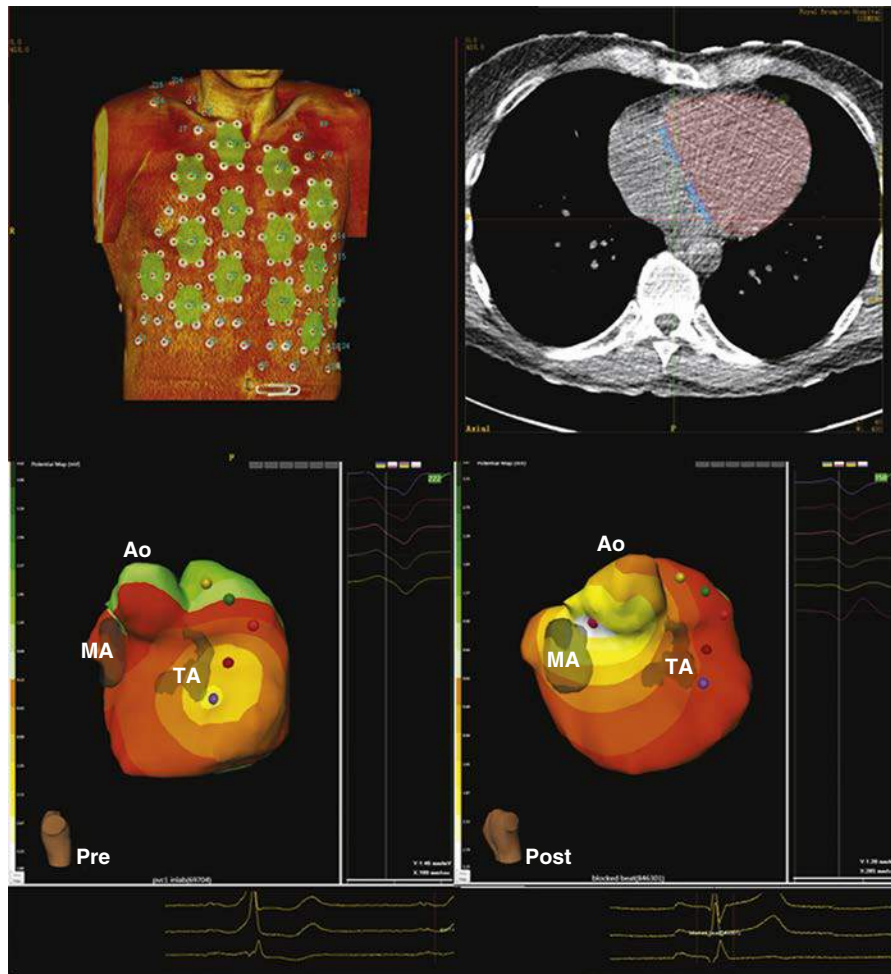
Example of a simultaneous mapping system that reconstructs the surface ECGs of 252 electrodes (*left upper panel*) on the atrial or ventricular epicardial three-dimensional (3D) reconstructions from a noncontrast computed tomography (CT) scan (*right upper panel*). Bottom panels display the 3D mapping information with and without antegrade conduction across an accessory pathway (AP) in posterolateral orientation of the tricuspid annulus (TA) in a patient with Ebstein anomaly. Ao, Aorta; MA, mitral annulus.
